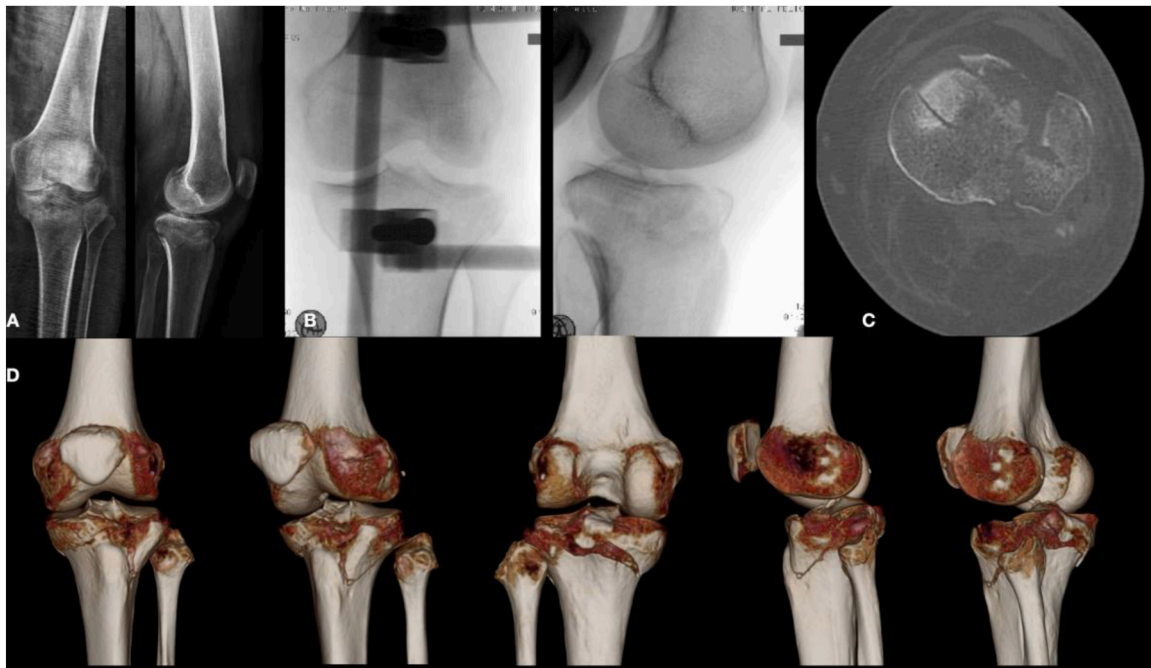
A 58-year-old female patient, physical education teacher, fell down the stairs and presented a bicondylar tibial plateau fracture. A: Radiographs in anteroposterior and lateral projections showing the hyperextension mechanism. B: Intraoperative fluoroscopy images after spanning the fracture. C: Axial projection in the CT-scan showing the involvement of the anteromedial and posteromedial quadrants of the tibial plateau. D: 3D reconstruction of the computed tomography. Observe the impacted area at the anterolateral surface of the tibial plateau, associated with split wedge fragments located in the anteromedial and anterolateral quadrants. Observe the loss of the posterior medial hinge (tension failure). This injury was classified as a tibial plateau fracture dislocation Type V AL + AM + PM [23,29].
